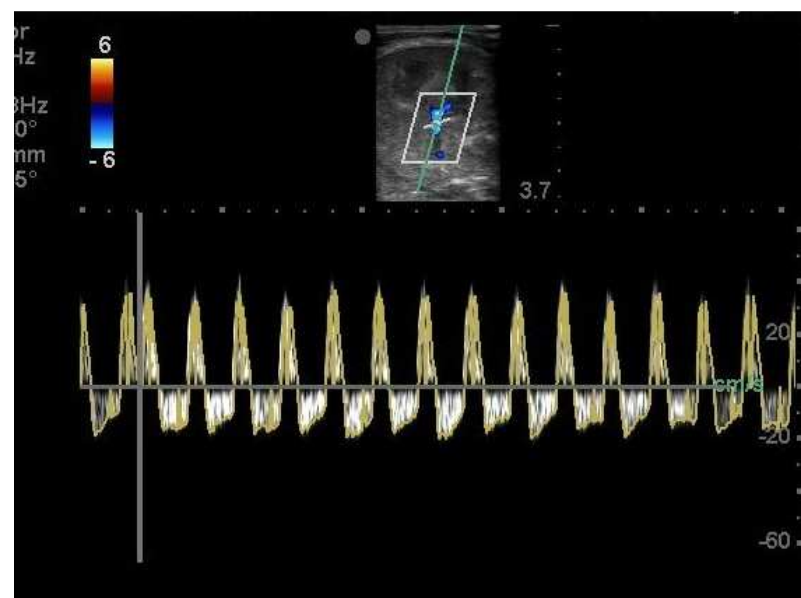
Reversal of left renal arterial doppler flow.
